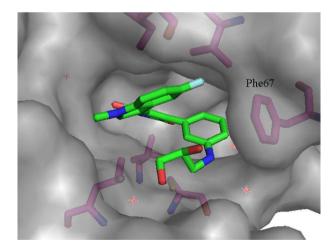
X-ray of 34 bound to GSK-3β.
